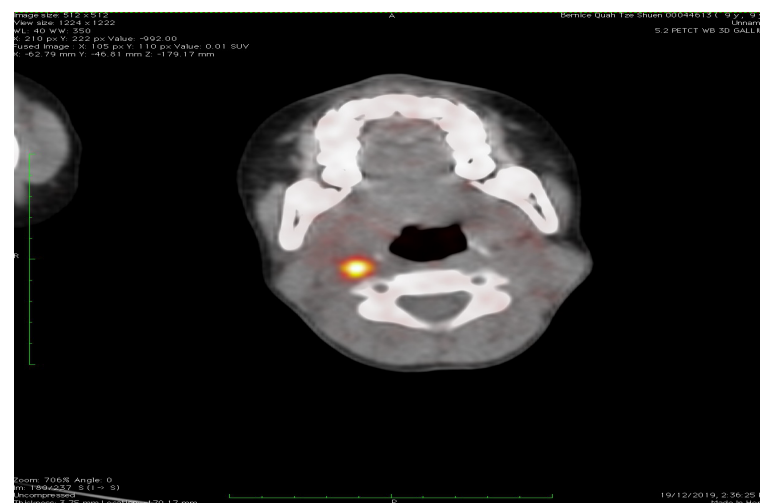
Focal of Ga-68 DOTATATE uptake seen at the hypodense lesion at right level II cervical region (SUVmax 21.0) measuring 1.0 x 0.8 cm on CT
